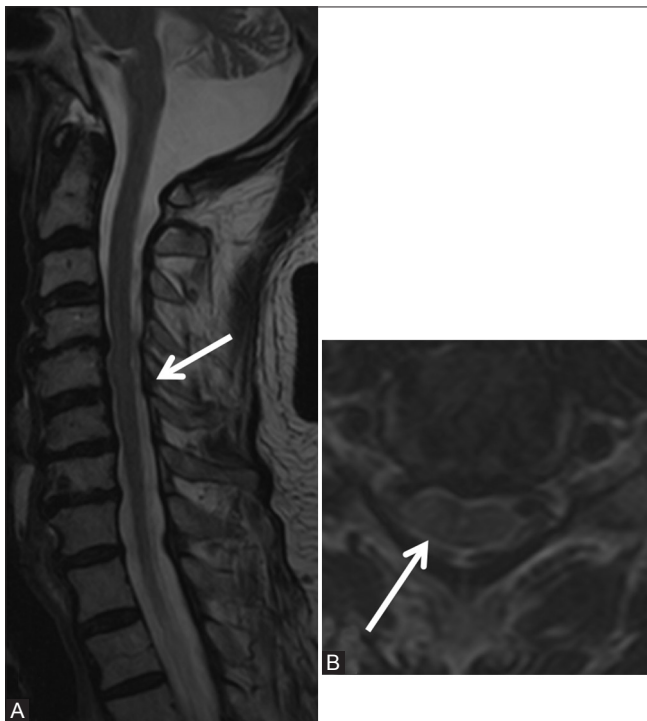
(A and B): Miscellaneous: Spontaneous epidural hematoma: Follow-up scan after 3 months. Sagittal (A) and axial (B) T2-weighted images show complete resolution of the posterior epidural hematoma (arrow)
